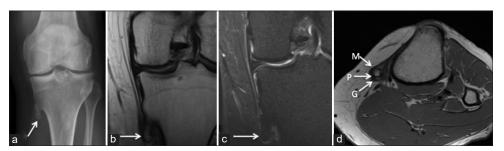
Anterior-posterior radiograph (a), T1 coronal (b), STIR coronal (c), and T1 axial (d) showing the pes anserine exostosis (arrow) (P) between the tibial component of the superficial medial collateral ligament (M) and gracilis (G).
